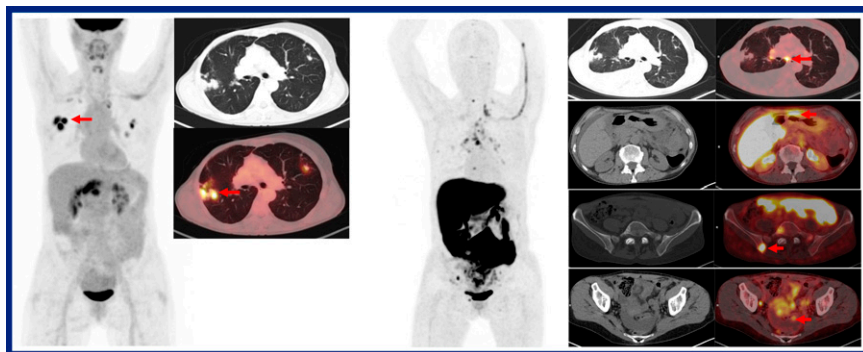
^{18}F -fluorestradiol (^{18}F -FES) PET/CT vs standard-of-care imaging in newly diagnosed and suspected recurrent breast cancer. Comparative ^{18}F -FDG PET/CT (left) and ^{18}F -FES PET/CT (right) imaging in a 59-y-old woman with previously treated invasive lobular breast cancer and elevated tumor markers. Benign granulomatous inflammation produced false-positive findings for lung recurrence (arrows) on ^{18}F -FDG PET/CT; these lesions were not ^{18}F -FES avid. However, many ^{18}F -FES–avid nodal, gastrointestinal, osseous, and peritoneal metastases (arrows) were missed on ^{18}F -FDG imaging. Tissue sampling of a peritoneal lesion demonstrated recurrent lobular breast cancer.
